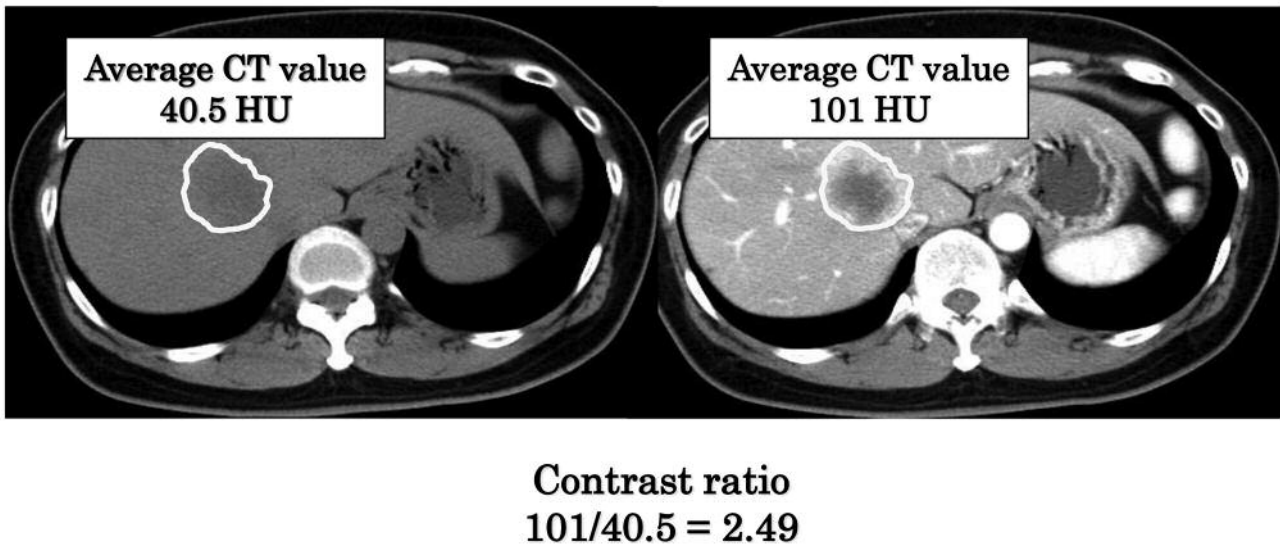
For the evaluation of the whole metastatic lesion by computed tomography (CT), the outer edge of the metastatic lesion was surrounded using a freehand tool on a monitor.
